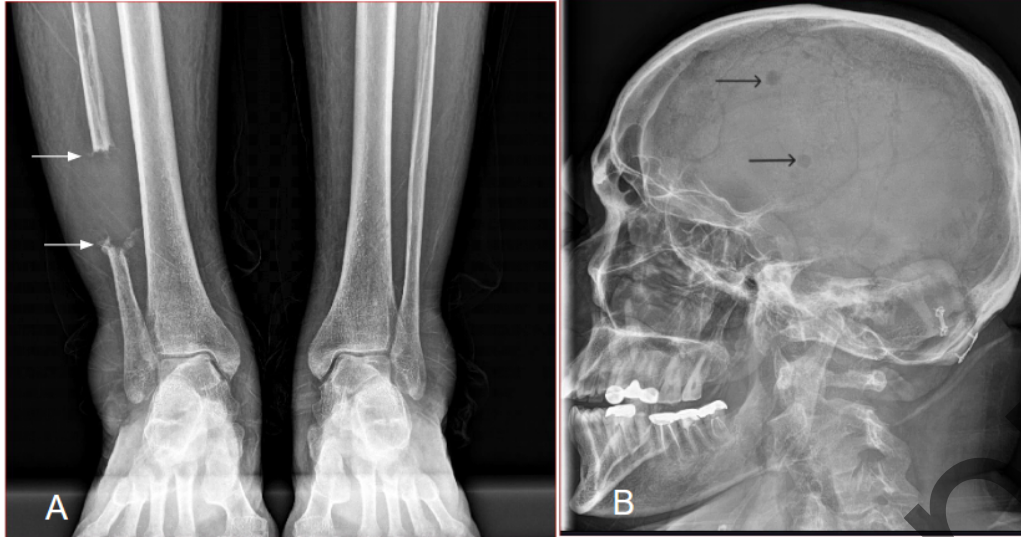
A. AP view of bilateral lower legs revealed a completely lytic lesion resulting in absence of a focal segment of distal fibula. The proximal and distal margins show irregularity and expansion (arrows). B. Radiograph of the skull (lateral view) shows punched out lytic lesions (arrows). Findings were suspicious for multiple myeloma or metastasis.
